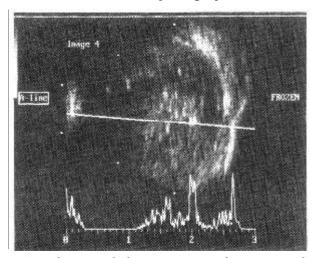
Ultrasound showing intraocular mass with no extraocular extension.
